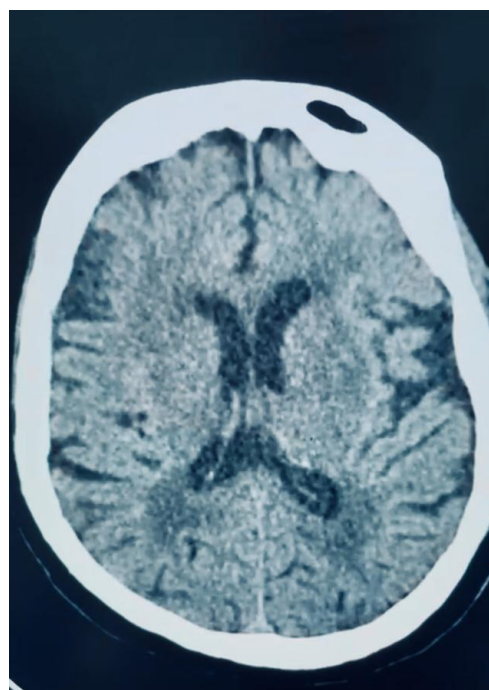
Follow up CT scan after 5 days following treatment initiation shows resolution of the pneumocephalous
